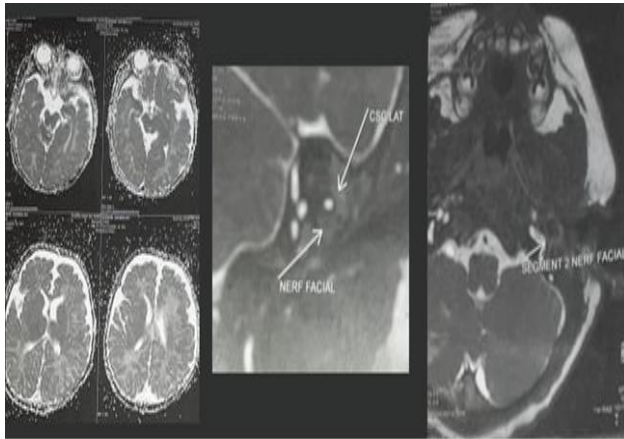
MRI axial views scans at 6 days of life showing congestion of the right middle ear reaching the right facial nerve.
